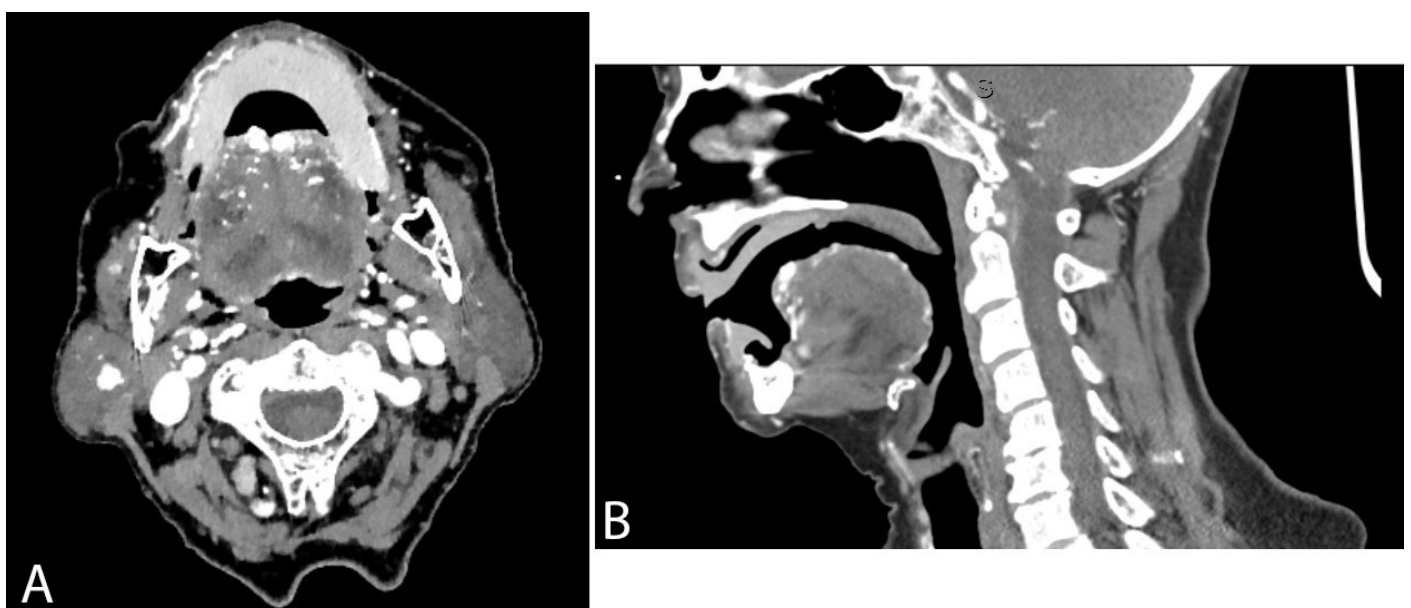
Computed tomography angiogram of the tongue. (A) Axial and (B) sagittal views demonstrating multiple enlarged, abnormal vessels bilaterally in the anterior third of the tongue.
